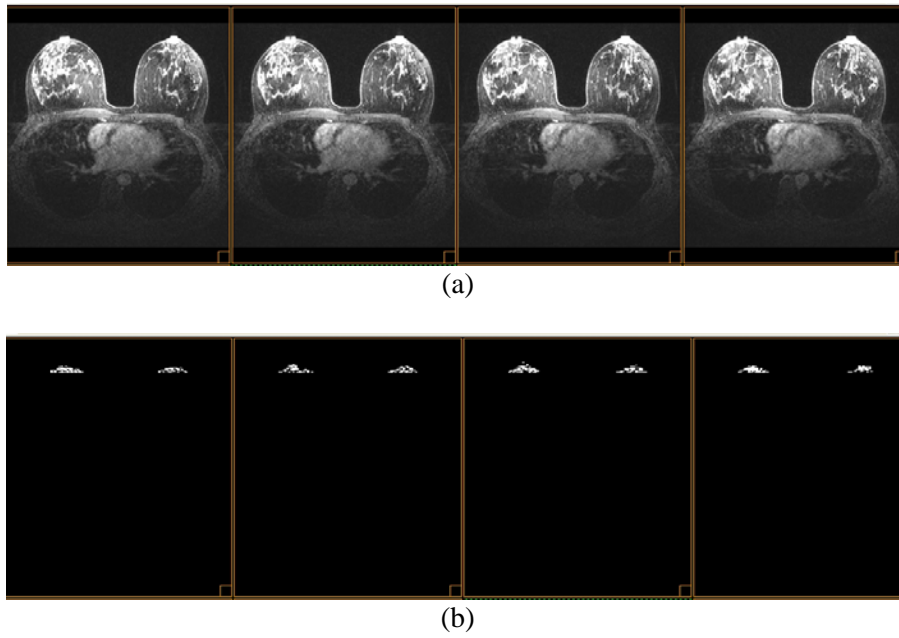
Example of the 3-D LDSERS results of MR Breast volume. (a) Four consecutive images of the MR volume with a partial digital signature embedded; (b) The subtracted images between the four original MR images and (a) showing where the digital signature is embedded.
